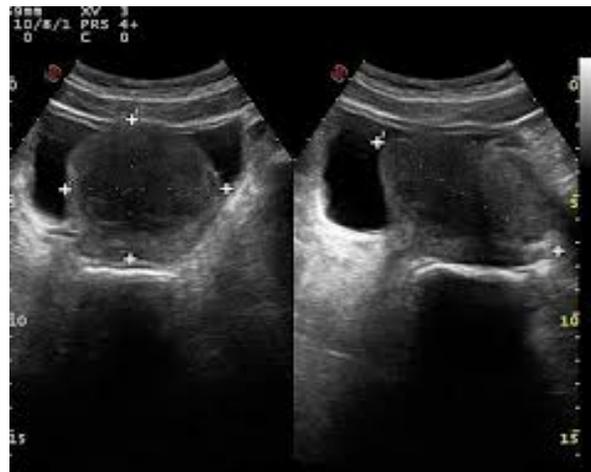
Ultrasonographic measurement of prostatic volume
